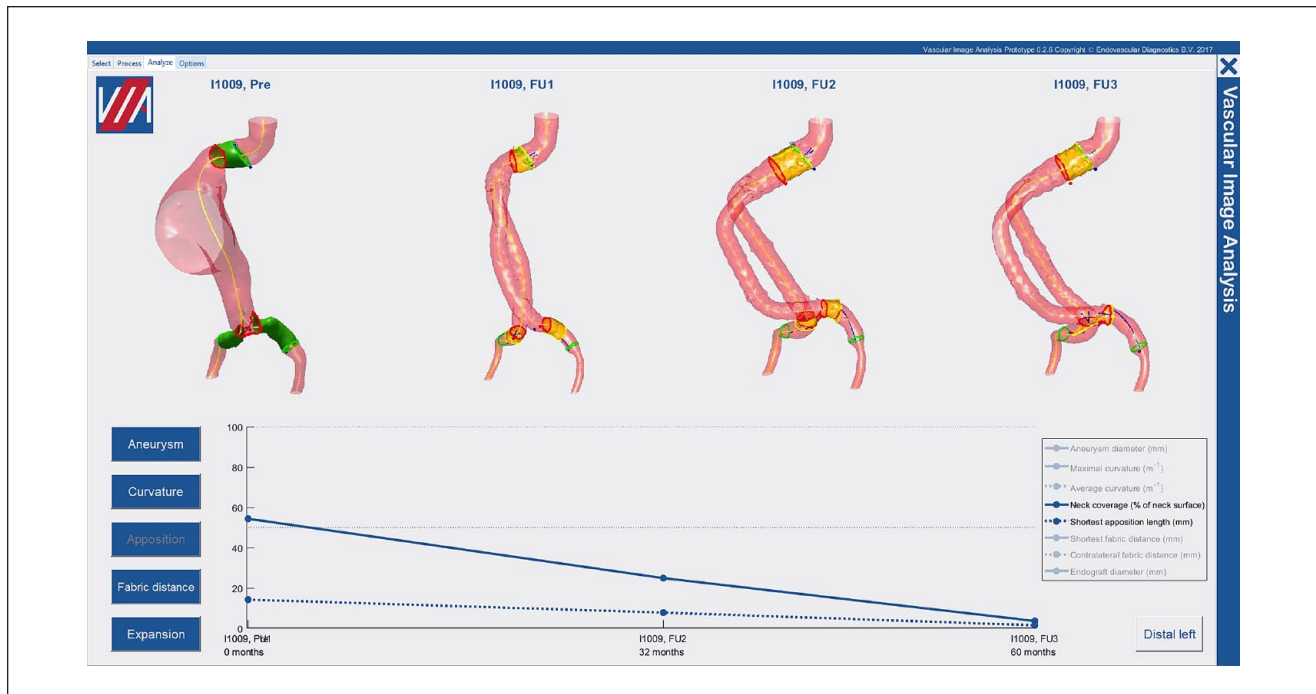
Overview of pre- and post-endograft computed tomography (CT) analysis in VIA prototype software. The 3-dimensional (3D) coordinates of the anatomical landmarks, the edges of the endograft fabric, the centerline, and a mesh of the aortic lumen are exported from a vascular workstation. Apposition surface areas (yellow), shortest apposition lengths, fabric distances, and fabric edge diameters are calculated automatically from these 3D coordinates. Changes in apposition, fabric distance, or endograft expansion measured at the distal end of the endograft limb are displayed in the software for consecutive CT scans. In this example, the decrease of apposition surface (solid line) and shortest length of apposition (dotted line) are displayed for the distal left limb. The proximal apposition was stable, while distal apposition decreased in both limbs.
